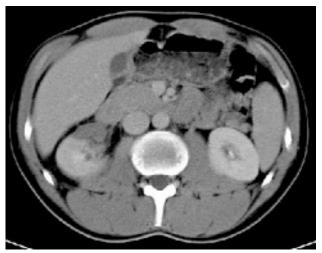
Abdominal CT scan showing avascular retracted post-traumatic scar in renal parenquima.
